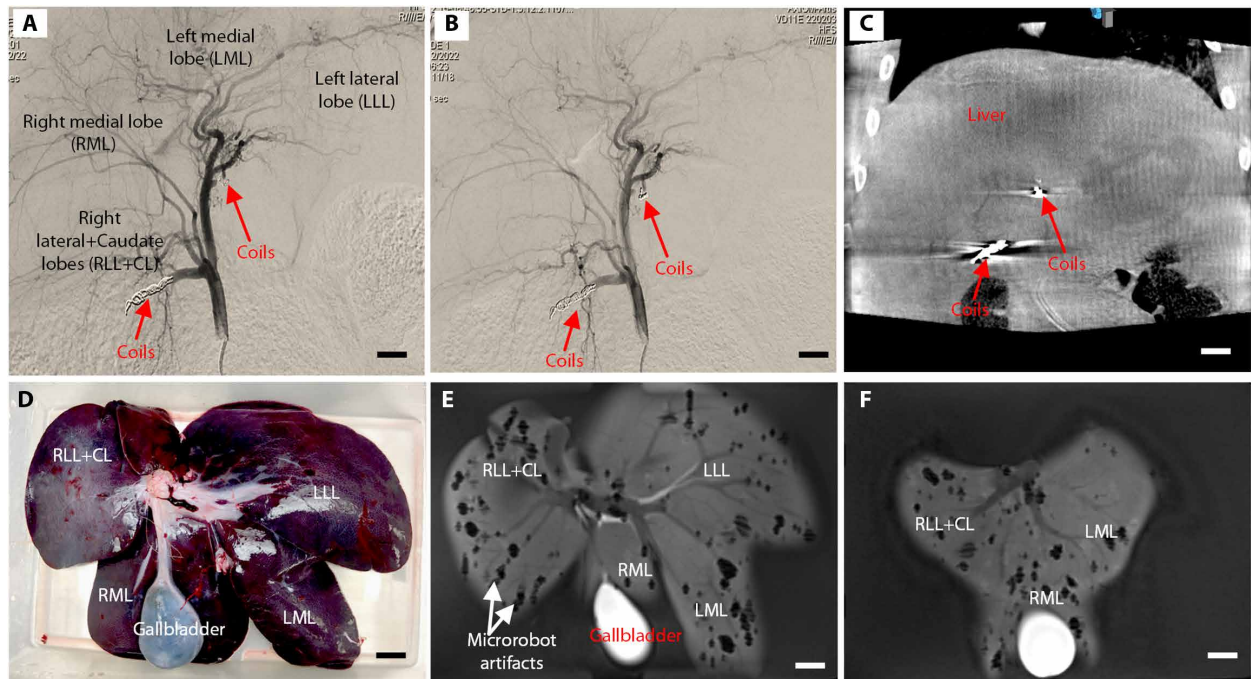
Liver distribution of MMR after injection in the angiography room without magnetic field. (A) Angiography showing the anatomy of the liver before embolization. The left gastric and gastroduodenal arteries were embolized with coils before the injection of the microrobots to prevent embolization in the stomach or duodenum. Scale bar, 1 cm. (B) DSA acquisition after microrobot injection showing no evidence of flow occlusion and no visibility of microrobots. Scale bar, 1 cm. (C) CBCT showing no visibility of microrobots. Only the coils positioned in left gastric and gastroduodenal arteries are visible (arrows). Scale bar, 1 cm. (D) Gross pathology with the caudal view of liver lobes annotated in white. Scale bar, 1 cm. (E and F) Particle distributions in two slices of the T1-VIBE images of (D). Scale bars, 1 cm (E and F).
